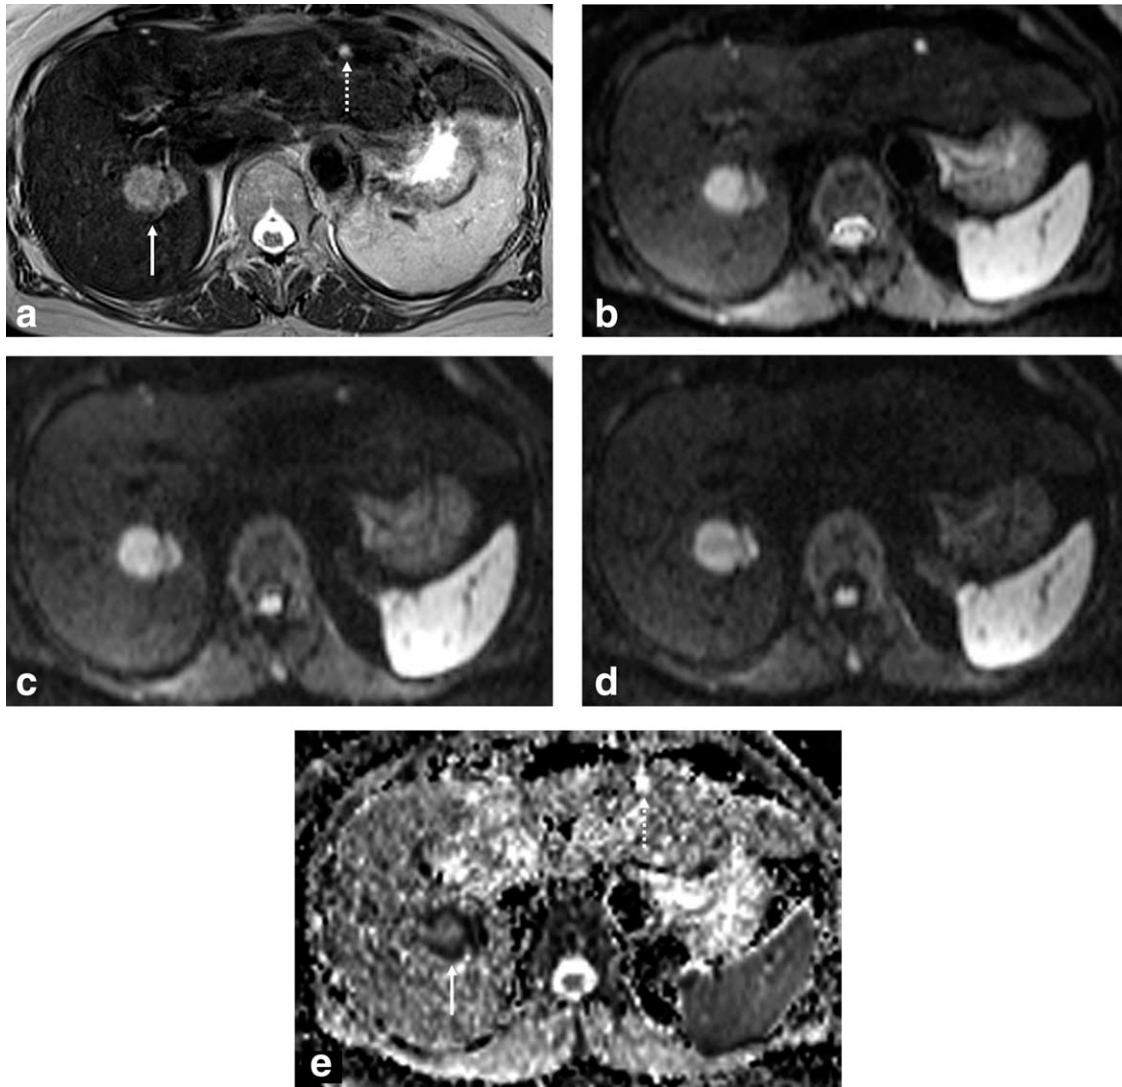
Metastasis from colon cancer and small cysts in a 67-year-old man. Transverse T2-weighted image (b-d). Transverse DWIs obtained with b-values of 50 (b), 400 (c), and 800 (d) s/mm^2 , (e) ADC map. At T2WI (a), metastasis (solid arrow) in segment VI is moderately hyperintense and a small cyst (dotted arrow) in segment III shows marked hyperintensity relative to surrounding liver parenchyma. On navigator-triggered DWIs (b-d), the metastasis with restricted diffusion is moderately hyperintense at a b-value of 50 s/mm^2 and the signal is largely retained at a b-value of 800 s/mm^2 , which is compatible with a malignant lesion. On the other hand, the small cyst containing free water is markedly hyperintense at a b-value of 50 s/mm^2 and the signal completely disappears at a b-value of 800 s/mm^2 , which is a typical feature of a benign lesion. On the ADC map (e), the metastasis is hypointense (solid arrow), which corresponds to a low ADC ($0.89 \times 10^{-3} \text{mm}^2/\text{s}$) and the small cyst shows distinct hyperintensity (dotted arrow) with a high ADC ($2.97 \times 10^{-3} \text{mm}^2/\text{s}$) relative to the surrounding liver parenchyma.
